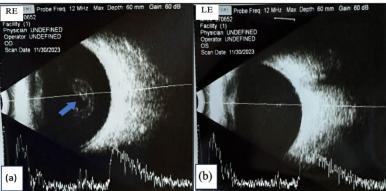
Examination of the right eye by ultrasonography (USG) revealed mild to moderate opacity of the vitreous with suspected inflammatory cells (a) shown in blue arrow; Examination of the left eye by USG was within normal limits (b). RE: Right Eye LE: Left Eye
